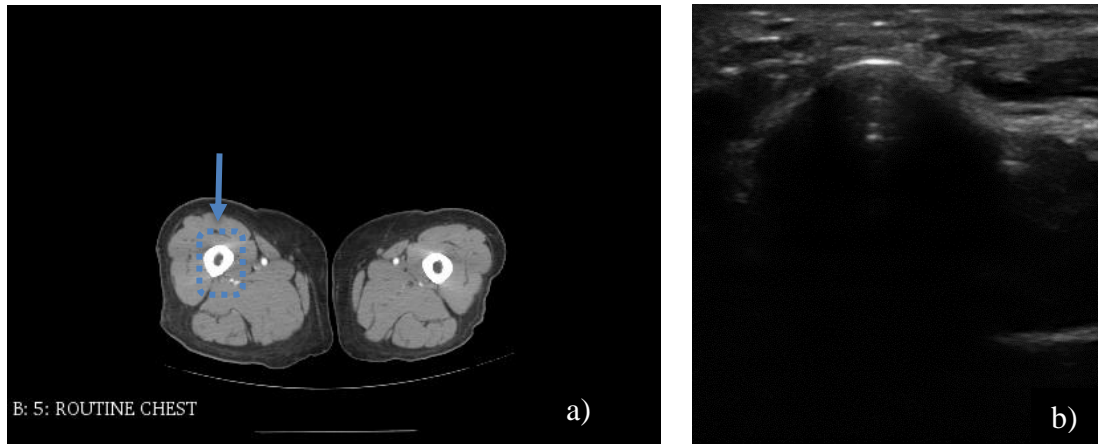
(a): example CT scan slice from a femur in cortical view. The blue dashed rectangle and the arrow highlight the approximate location and rotation of the US image, respectively. (b): US image of the bone from the same femur in the left.
